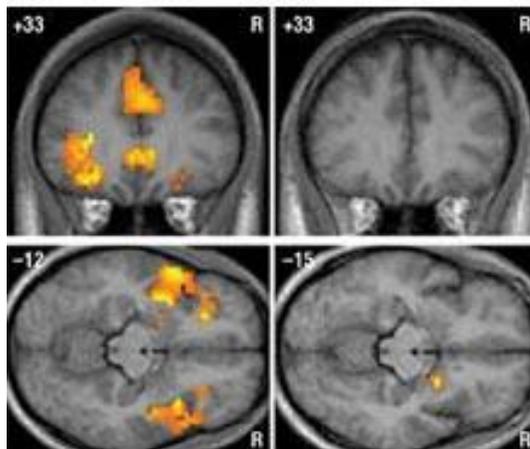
Brain MRI - brain activity in the empathy-generating centers of the limbic system in normal individuals (left) and psychopathic individuals (right) when exposed to a violent image
